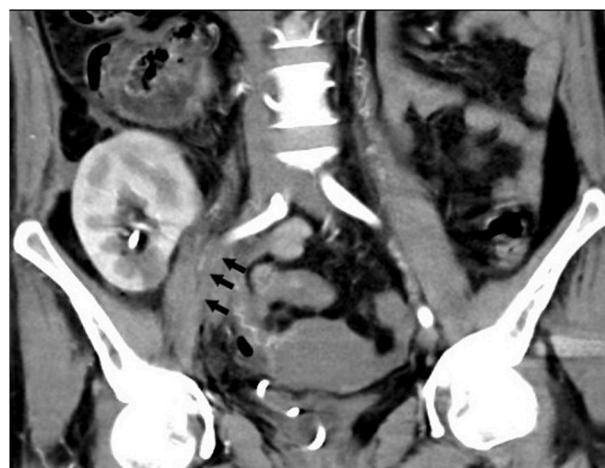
Computed tomography angiogram showing dissection of the right external iliac artery (arrows).
